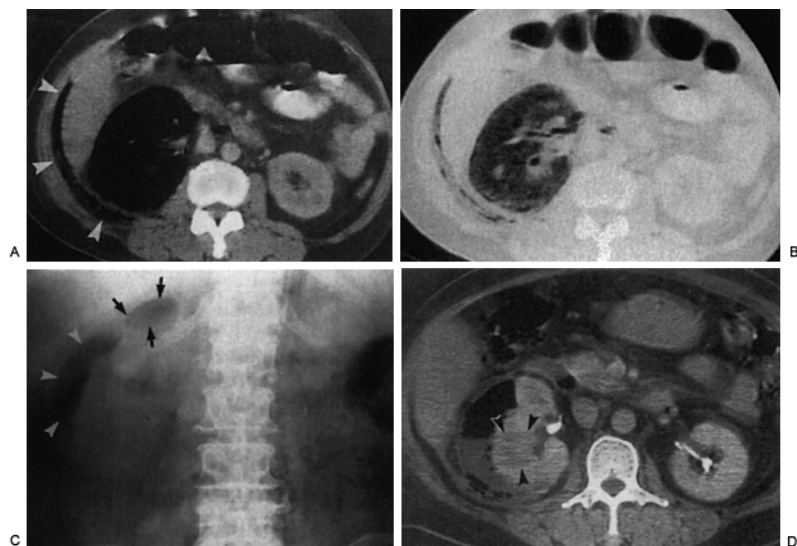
A, B: Type I emphysematous pyelonephritis (EPN) with complete renal destruction in a 49-year-old woman. A: Computed tomography (CT) scan of the right kidney shows complete destruction with gas (*arrowheads*) extending beyond the renal fascia. B: CT scan with a modified lung window display shows the characteristic streaky gas in the completely destroyed kidney. The patient died on arrival in the emergency department before nephrectomy was attempted. C, D: Type II EPN in a 57-year-old woman. C: Radiograph shows crescent-shaped (*arrowheads*) and loculated (*arrows*) gas in the right renal area. D: CT image obtained after administration of contrast material shows a low-attenuation area (*arrowheads*) in the right kidney due to acute pyelonephritis as well as a subcapsular abscess with fluid, bubbly, and loculated gas. The patient survived after percutaneous drainage was performed.
